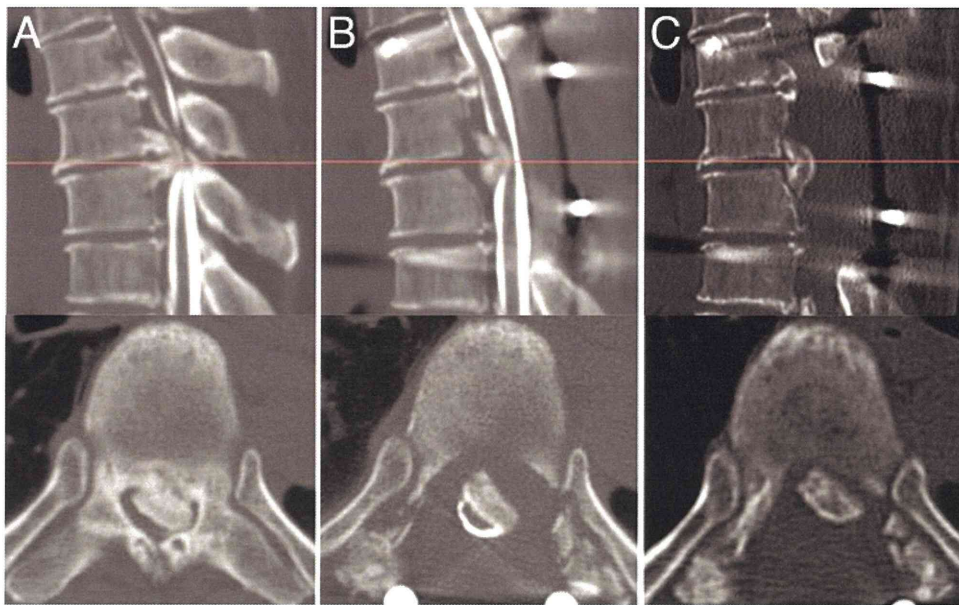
Case 5. OPLL at T5–6 treated by means of the plaque-floating technique. A and B: Preoperative (A) and 1-month postoperative (B) CT myelograms. C: Postoperative plain CT image obtained 6 months after surgery. Figure is available in color online only.
